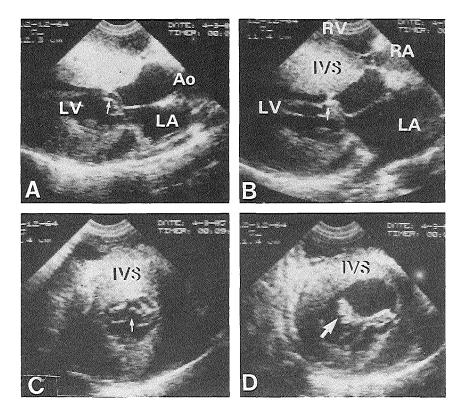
Intraoperative two-dimensional echocardiograms obtained in a patient with hypertrophic obstructive cardiomyopathy. The transducer was placed onto the right ventricular (RV) surface. The left ventricular long-axis view (A) and the modified four-chamber view (B) both revealed the hypertrophied interventricular septum (IVS) of approximately 30 mm thickness. The systolic anterior motion of both the anterior and posterior mitral valve leaflet is recognized in these images as well as in the short-axis view (C; small arrow). The left ventricular short-axis view obtained at a somewhat lower level (D) shows that the ventricular septal thickness was reduced (\pm 18 mm). In addition, in this cross-section a second obstruction was noted that was represented by an anomalous chord connecting the interventricular septum with the anterior mitral valve leaflet (solid arrow). RA = right atrium; LA = left atrium; LV = left ventricle
